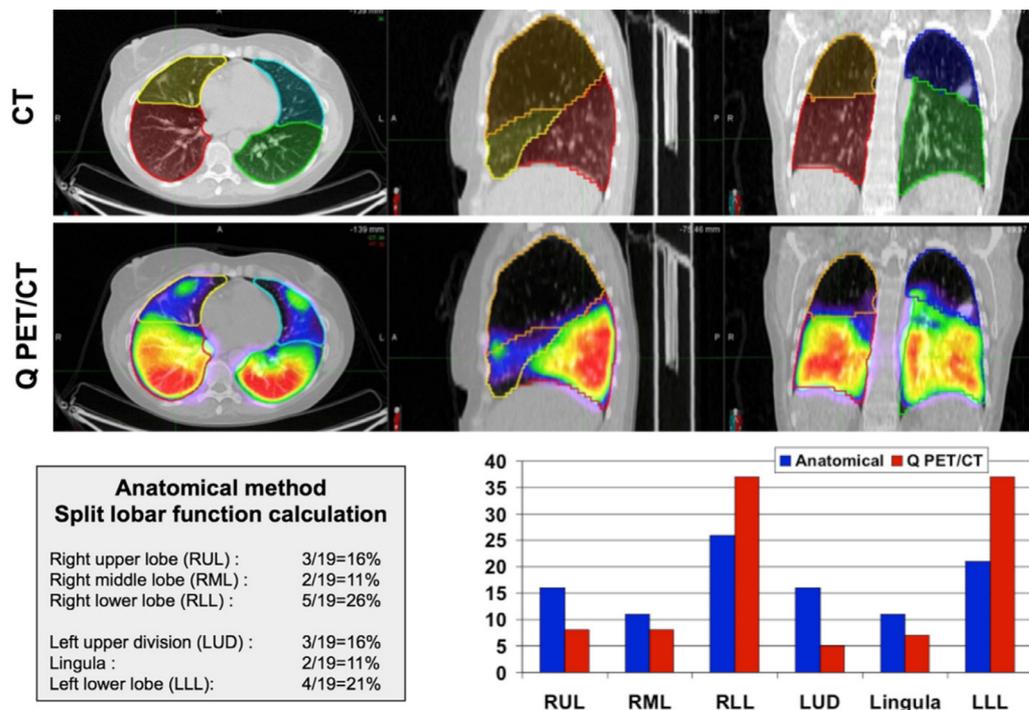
Two regional lung quantification analyses using ⁶⁸Ga-MAA PET/CT. In this example, there is significant discordance between lobar split function derived from volumetric CT analysis and functional perfusion analysis owing to emphysematous changes in the upper lobes. Planar three-zone scintigraphy (not shown) was also significantly discordant. The high-resolution images provided by perfusion PET/CT provide confidence to the cardiothoracic surgeon to enhance decision making.
